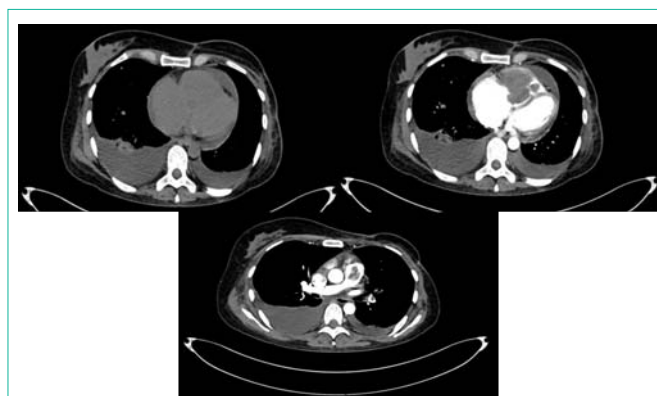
Computed tomography scans.
